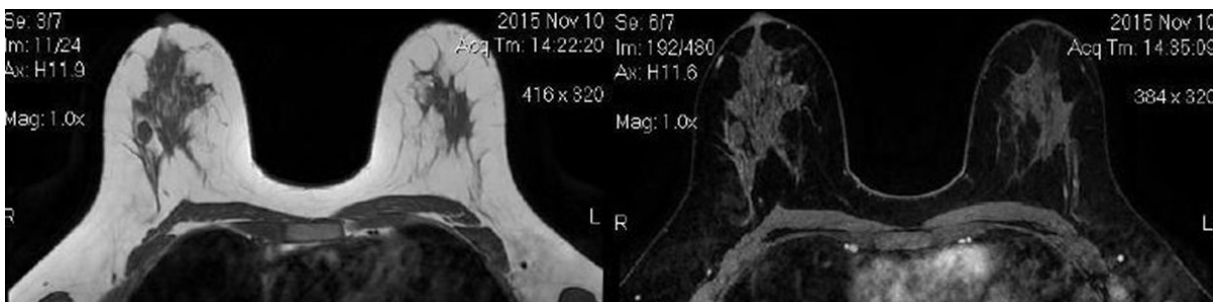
T1W MRI with and without contrast after 6 months shows a decrease in the size of the mass
